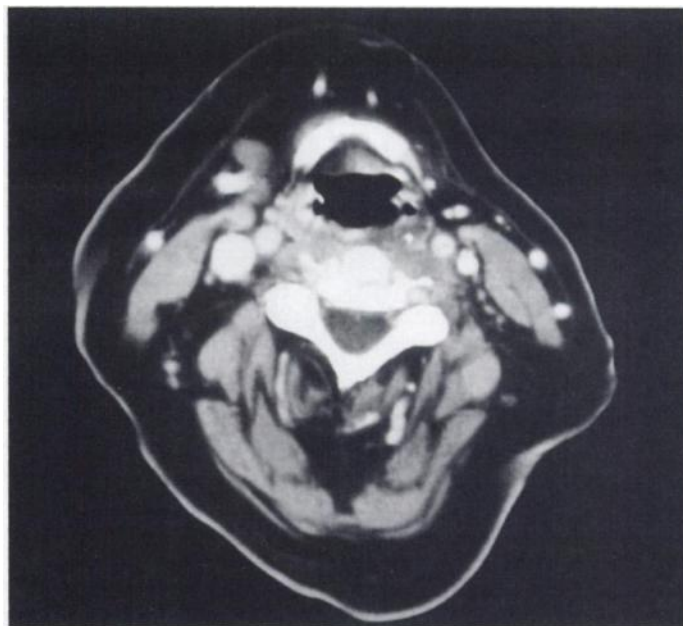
CT of the neck performed the same day reveals a normal-appearing epiglottis with no evidence of inflammation.
